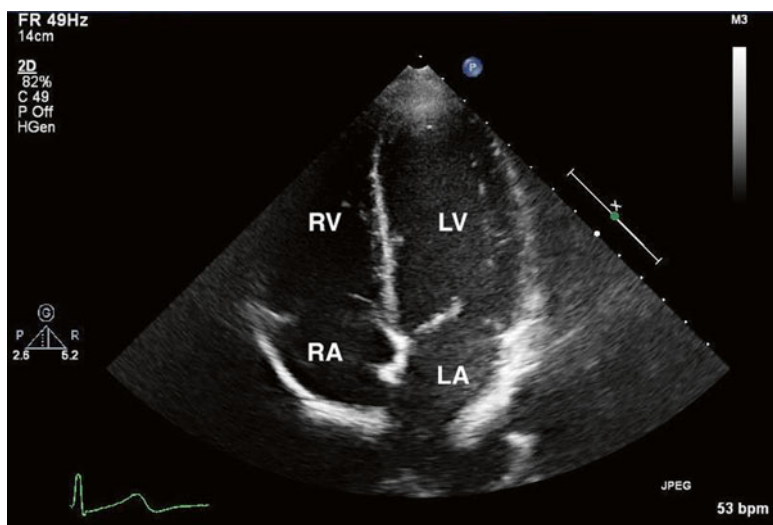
Apical four-chamber view. As per standard echocardiographic convention, the left sided chambers of the heart are displayed on the left side of the imaging screen. The right (RV) and left (LV) ventricles, and the right (RA) and left (LA) atria are partitioned by the interventricular and interatrial septa, which join at the fibrous trigone of the atrioventricular (AV) valves to form the crux of the heart. The atrioventricular valves (mitral and tricuspid) are visualized as well; note the apical displacement, relative to the anterior mitral valve leaflet, of the septal leaflet of the tricuspid valve
